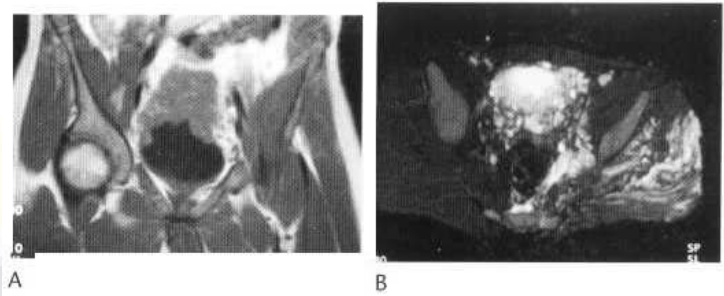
Coronal T-weighted (A) and transverse STIR (B) images from an MRI scan of the pelvis of a patient with an extensive pelvic haemangioma in association with Klippel-Trenaunay syndrome. There is a large lobulated mass over the dome of the bladder which is continuous with further dilated vessels running posteriorly in the left hemipelvis and into the left buttock.
